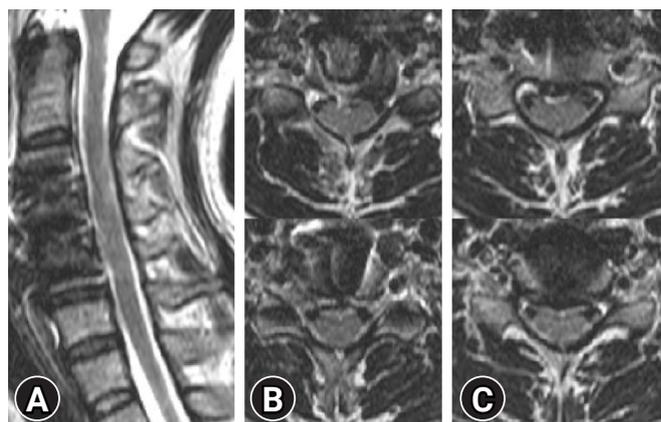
Postoperative images of the up migrated cervical disc herniation at C3-4, C4-5 level on MRI. (A) A mid-sagittal image on T2 weighted MRI. (B) Axial images at C3-4 level on T2 weighted MRI. (C) Axial images at C4-5 level on T2 weighted MRI.
